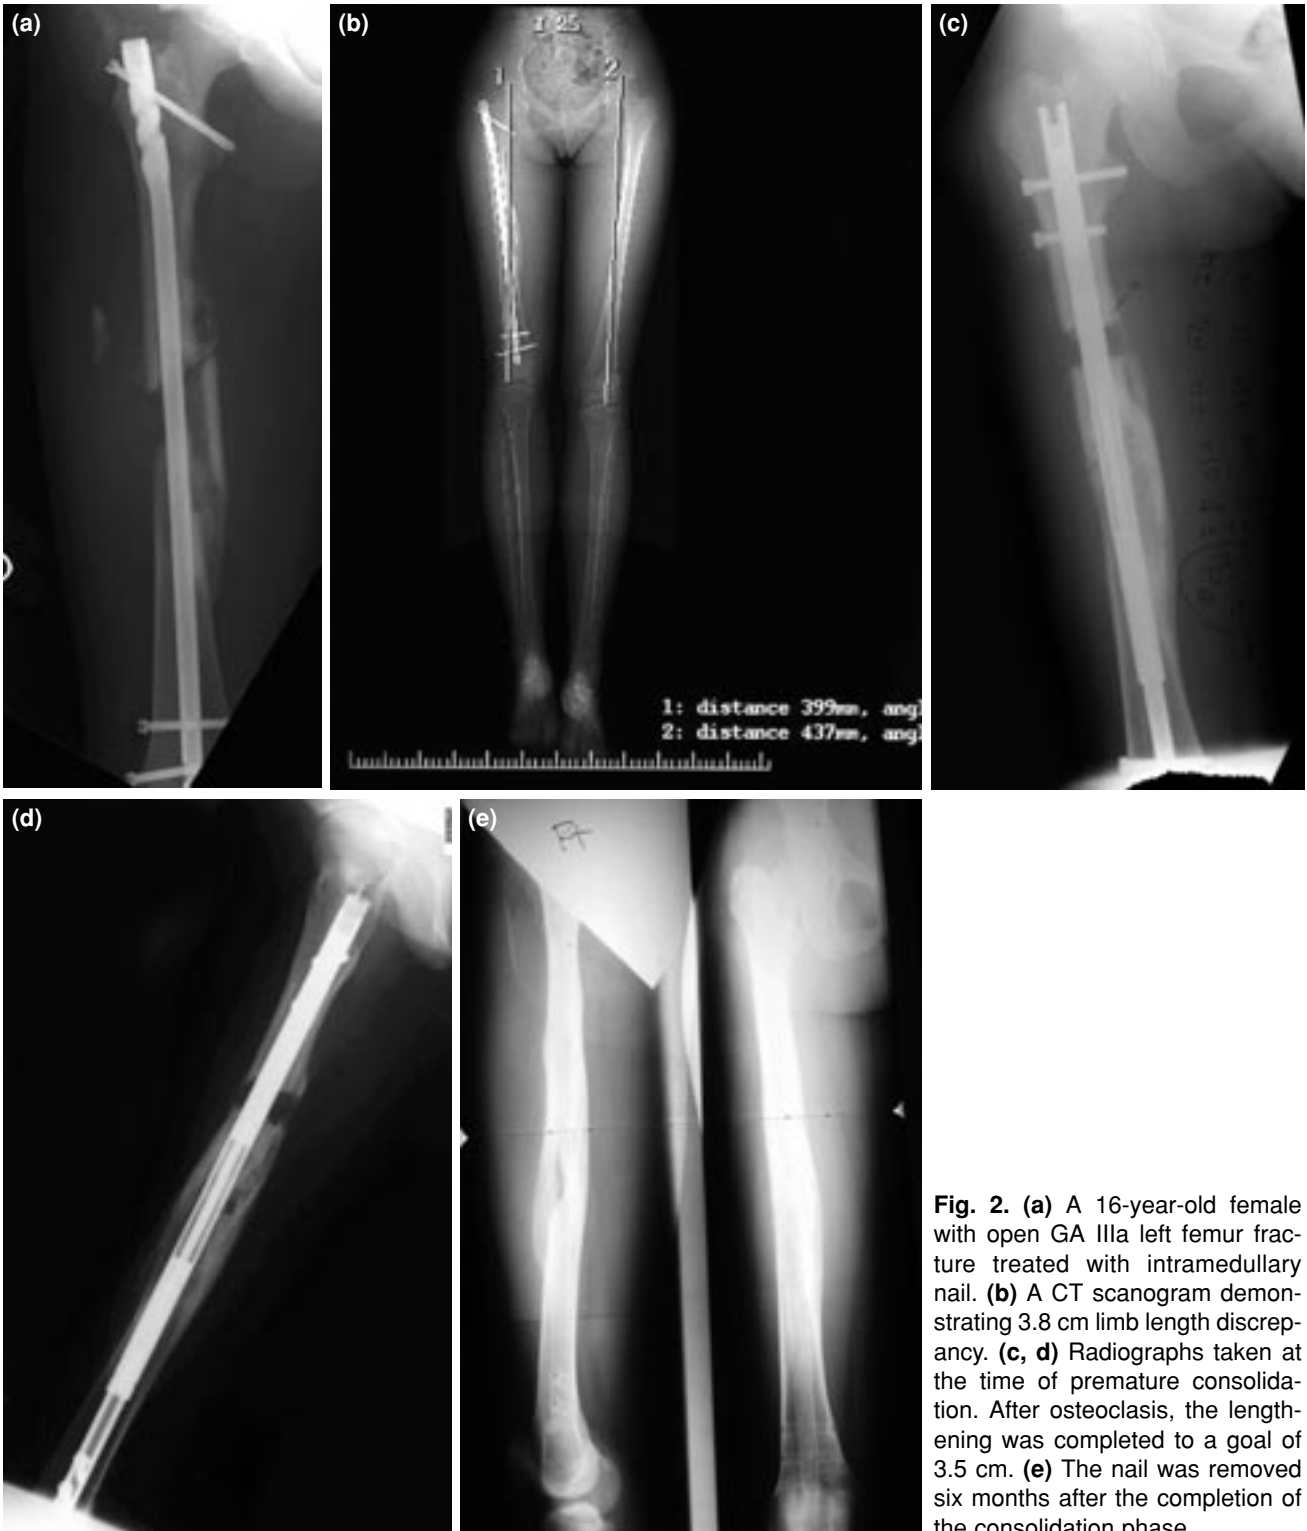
(a) A 16-year-old female with open GA IIIa left femur fracture treated with intramedullary nail. (b) A CT scanogram demonstrating 3.8 cm limb length discrepancy. (c, d) Radiographs taken at the time of premature consolidation. After osteoclasis, the lengthening was completed to a goal of 3.5 cm. (e) The nail was removed six months after the completion of the consolidation phase.
